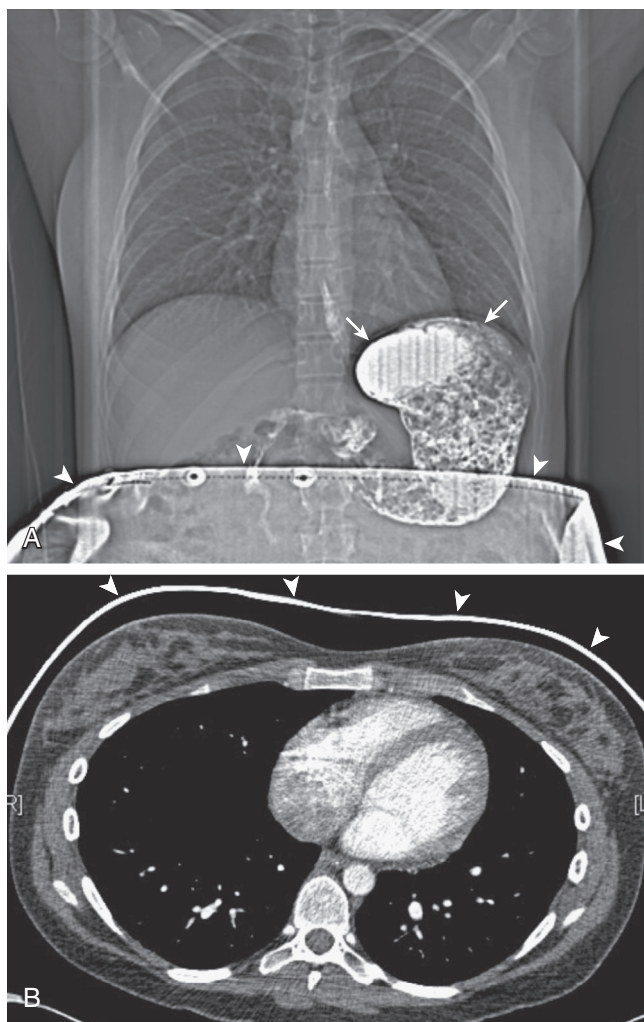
Dose-reduction methods for chest CT in the pregnant patient. A, Scout view before the CT acquisition shows an “internal barium shield” (arrows) created by having the patient swallow a dilute mixture of barium and water several minutes before CT scanning. The barium distributes within the stomach and proximal small bowel and attenuates internal maternal radiation that may otherwise expose the fetus. A lead apron (arrowheads) also reduces fetal radiation exposure. B, Axial chest CT pulmonary angiogram obtained with manual reduction of both the tube current and tube voltage shows excellent vascular opacification, providing high-quality assessment for pulmonary embolism and other thoracic disorders. A maternal breast shield (arrowheads) has also been placed; these shields selectively filter low-energy x-ray photons that would otherwise deposit preferentially in maternal breast tissue, significantly contributing to maternal breast radiation exposure. (Courtesy Michael Gotway, MD.)
